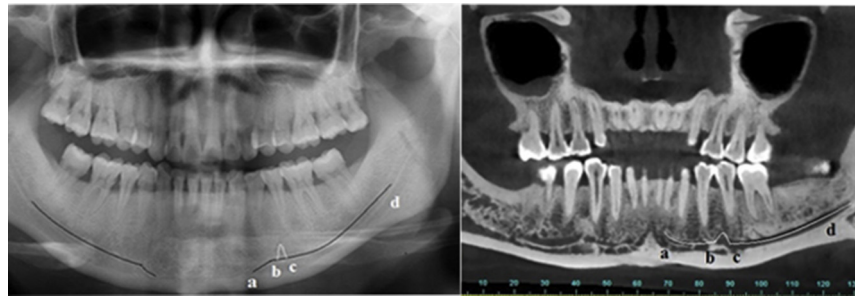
Mandibular incisive canal on panoramic radiograph (left panel) and CBCT (right panel): a–b, mandibular incisive canal; b–c, mental foramen; c–d, mandibular canal.
